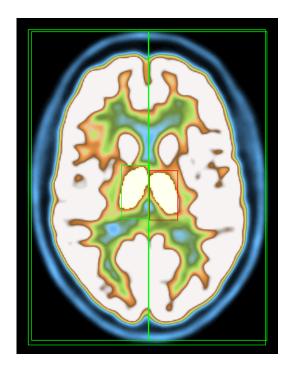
Example of PET/CT scan as presented in ROVER
